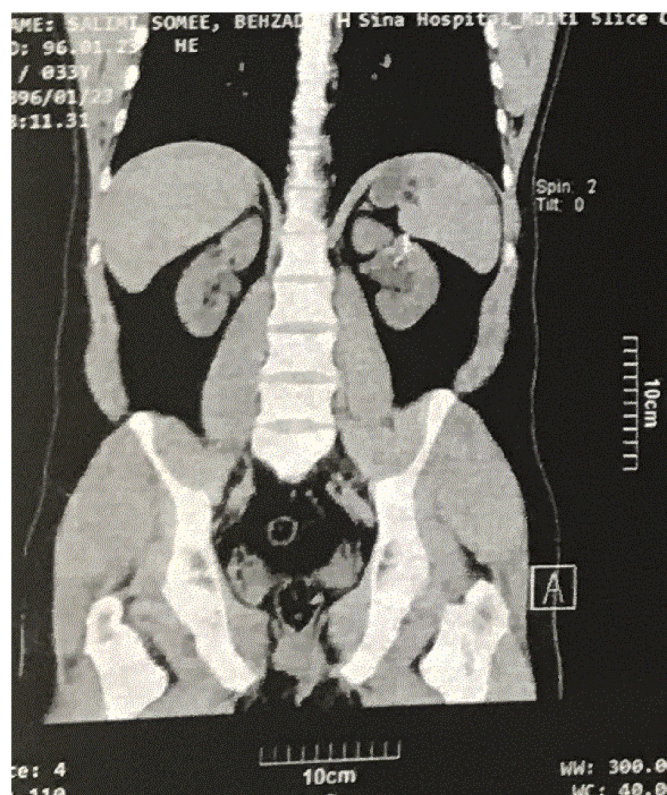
Non contrast CT scan showed a needle like object in the upper pole of left kidney.
